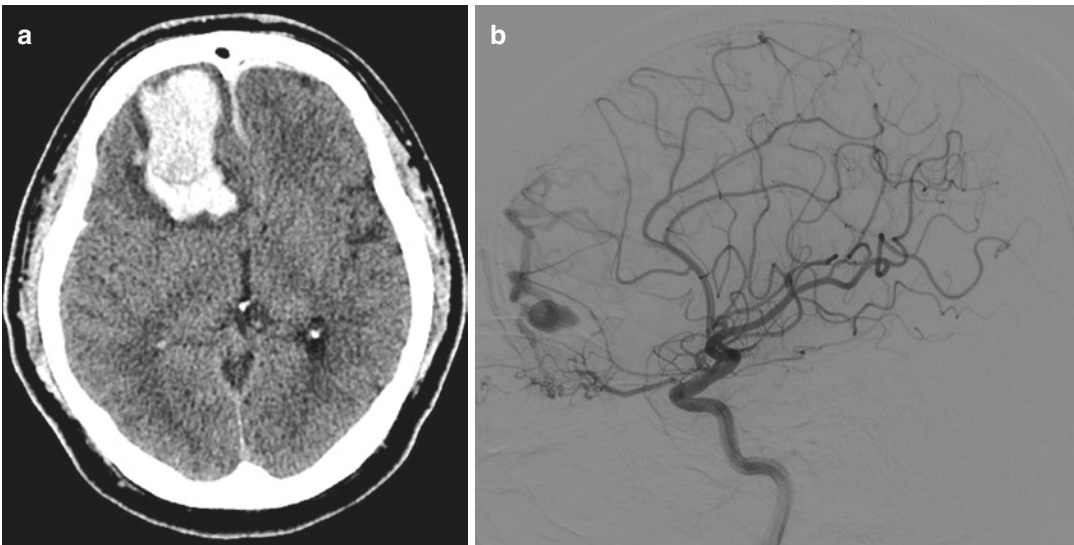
A 48-year-old man presented with consciousness degradation. (a) Computed tomography shows a large amount intracerebral hemorrhage at right frontal lobe and subdural hemorrhage around falx. (b) Digital subtraction angiography shows a dural arteriovenous fistula (DAVF) at anterior cranial fossa. The arterial feeders
